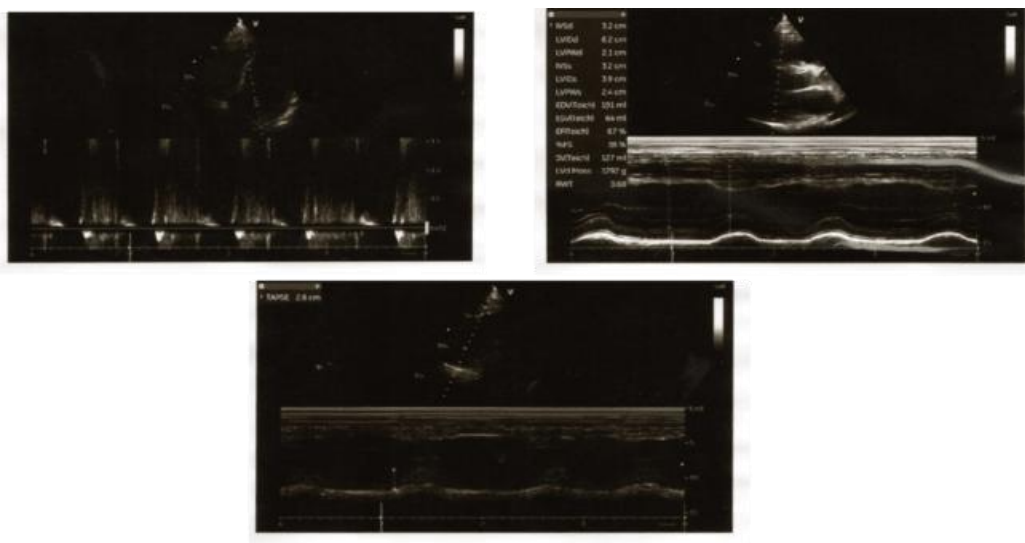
Echocardiography Results
